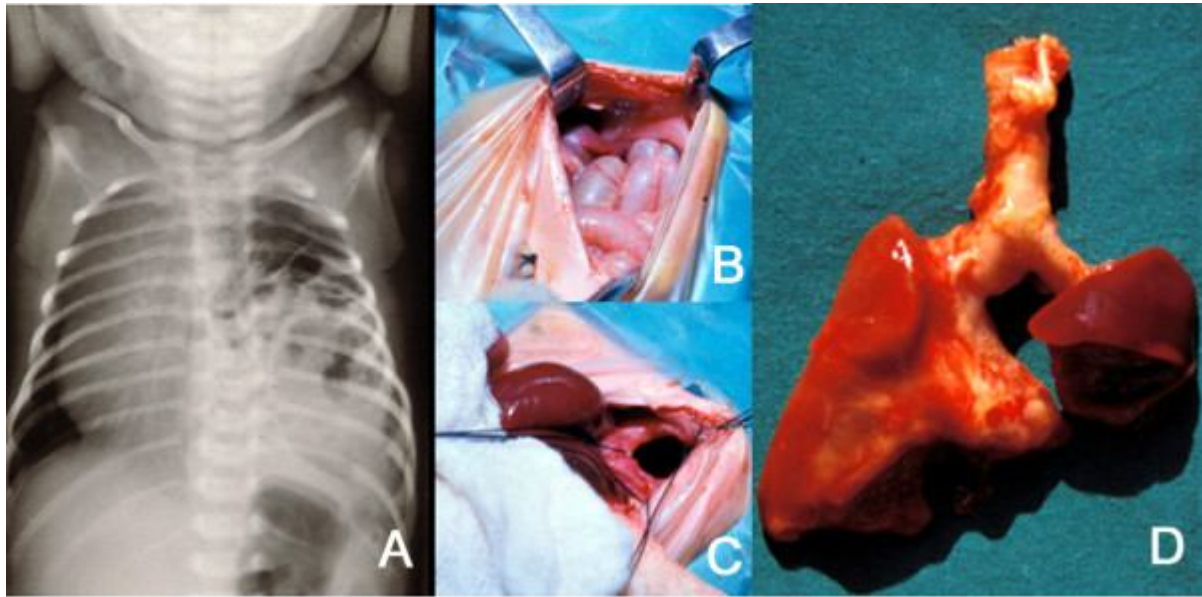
A: Plain X-ray of the thorax of a newborn with congenital diaphragmatic hernia (CDH). There are bowel loops in the left hemi-thorax, the mediastinum is displaced to the contralateral side and the space occupied by the lung is reduced. B and C: At laparotomy, a left, posterolateral diaphragmatic hernia was discovered. In B, small bowel loops can be seen entering the thorax through the orifice. In C, this is seen after reducing the contents of the hernia. D: The patient died of severe persistent pulmonary hypertension days later. At autopsy, extreme left lung hypoplasia and less severe right lung hypoplasia were discovered (Tovar 2012).
